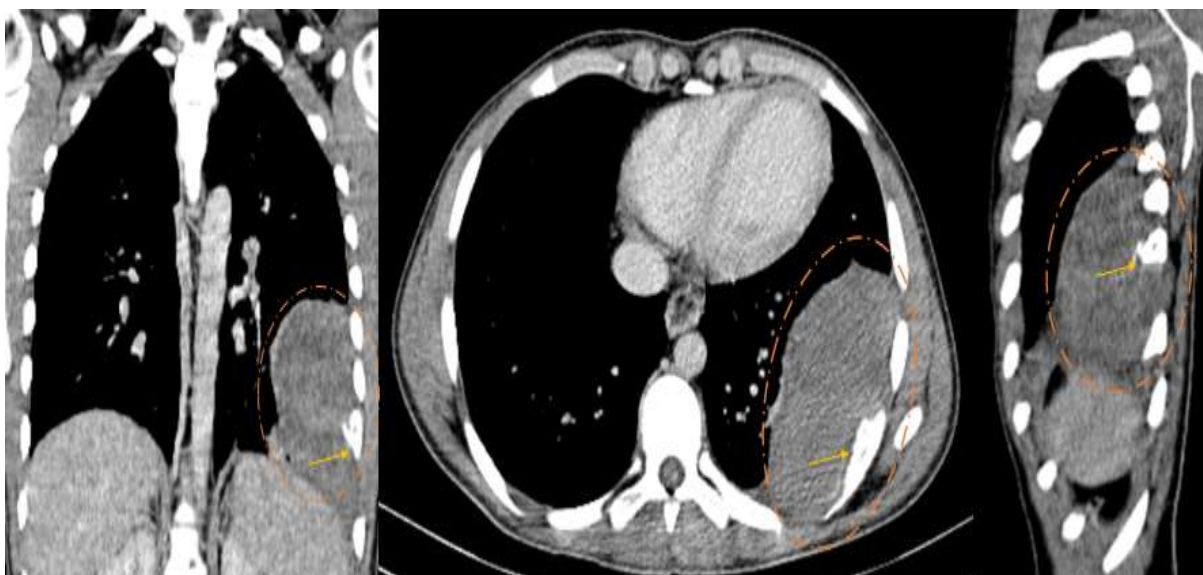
Interval contrast-enhanced CT of the chest (coronal, axial, and sagittal) showing a significant regression of the tumor mass, consistent with therapeutic response of the Ewing's sarcoma. Persistent osteolytic destruction of the ipsilateral 8th rib remains visible.
